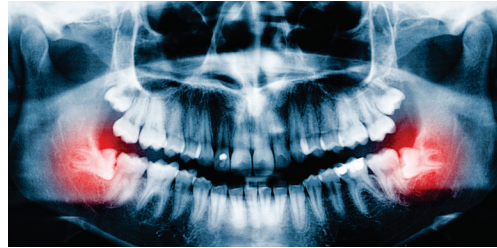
A panoramic x-ray showing two impacted wisdom teeth (highlighted in red) that require removal
